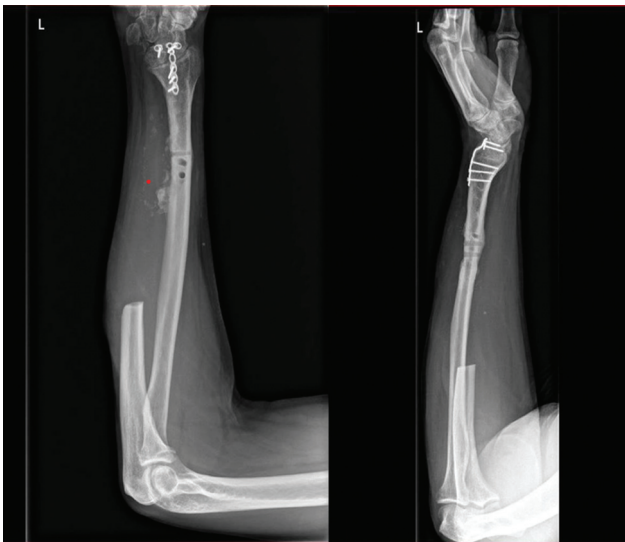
Anteroposterior and lateral X-rays of Case 3, after the removal of the osteosynthesis material and shortening the ulna at the proximal shaft.
